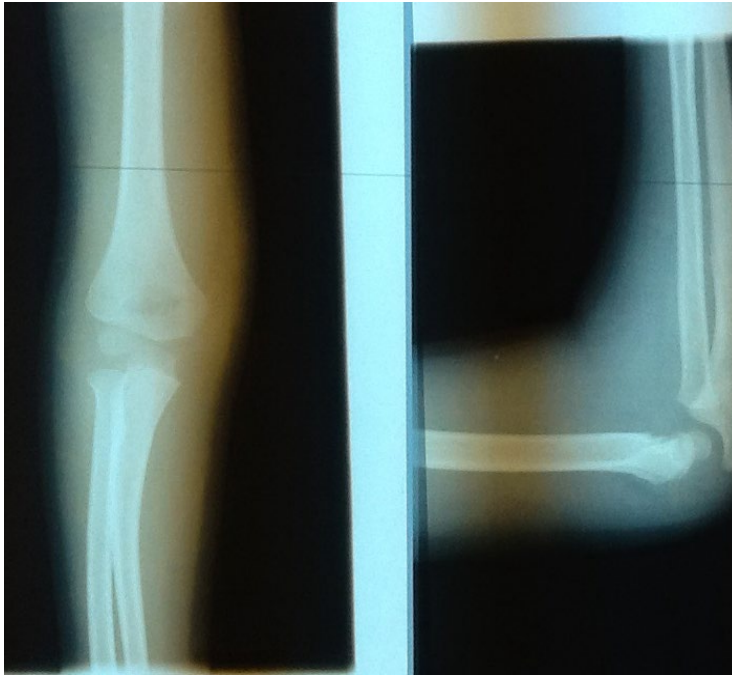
Anteroposterior (AP) and lateral x-ray views of patient from current study with type I fracture.
